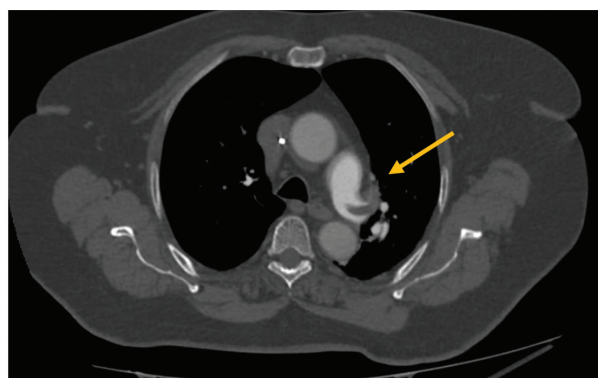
Baseline CTA showing saddle PE and bilateral PA thrombus.
